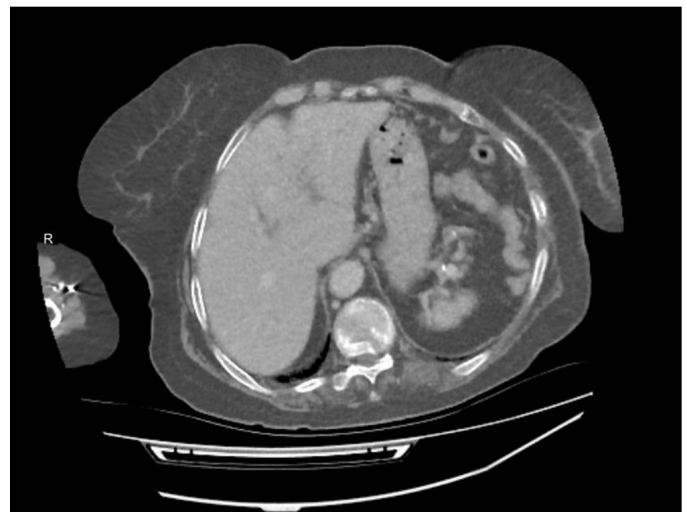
No hemorrhage was observed in the liver on the CT scan performed in the emergency department
